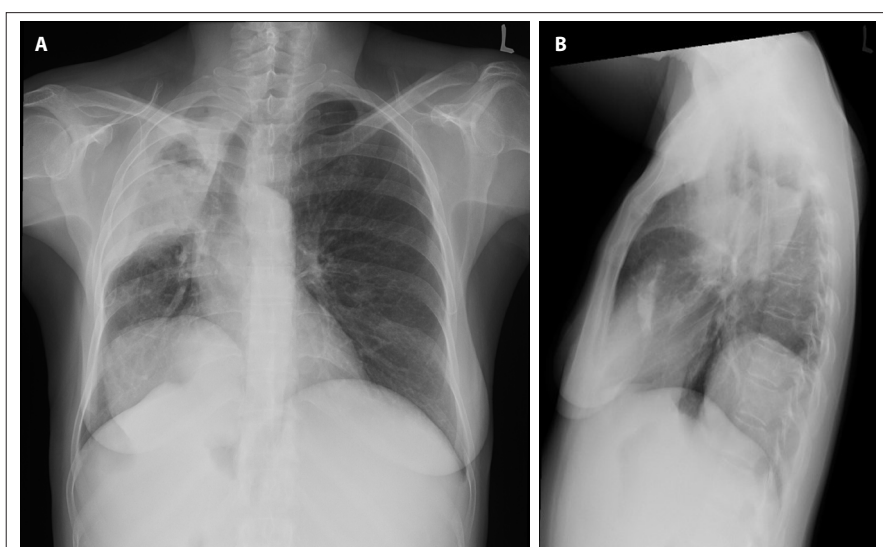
(A) Chest radiograph, showing right upper-lobe volume loss and intracavity mass, as well as large posterior right lower-lobe cyst. (B) Chest radiograph, showing large posterior right lower-lobe cyst.
